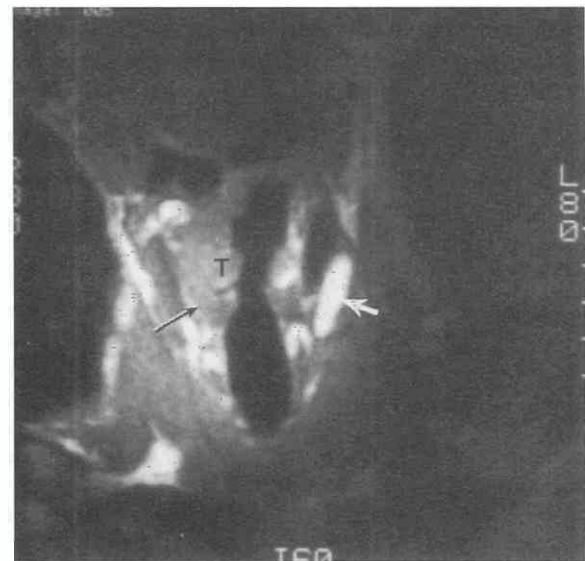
Supraglottic carcinoma extending around the ventricle into the lateral cord. The tumor (T) is readily visible to the endoscopist. A small amount of tumor (arrow) is seen extending around the lateral aspect of the ventricle into the superolateral margin of the thyroarytenoid muscle (TAM). The mucosa at the true cord level was normal. Thyroid cartilage is represented by a white arrow. (From Curtin HD: MR and CT of the larynx. In Thrall JH [ed]: Current Practice of Radiology, 3rd ed. St. Louis, Mosby-Year Book, 1994.)
